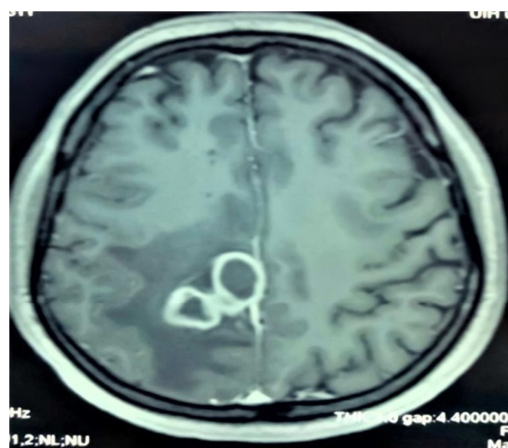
MRI brain tuberculosis cocardial image.
